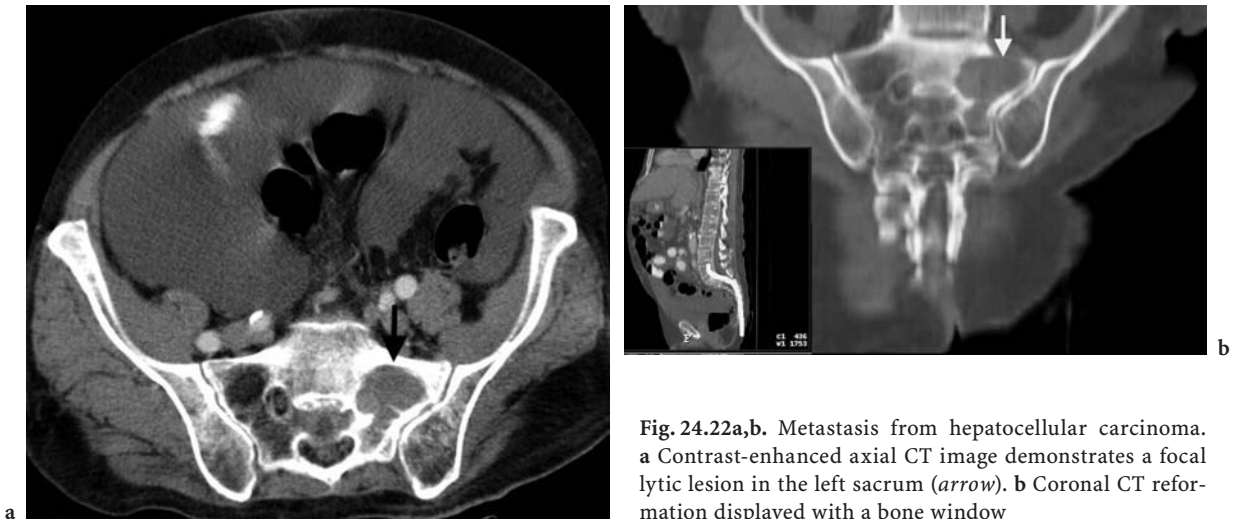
Metastasis from hepatocellular carcinoma. a Contrast-enhanced axial CT image demonstrates a focal lytic lesion in the left sacrum (arrow). b Coronal CT reformation displayed with a bone window
